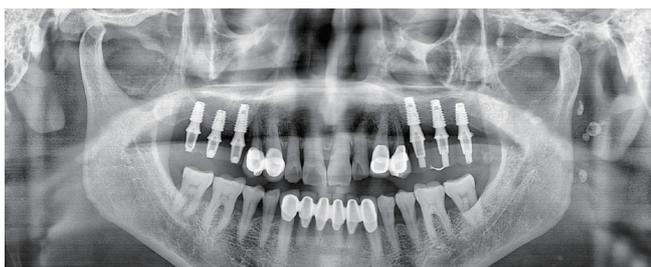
Panoramic x-ray right after installation
